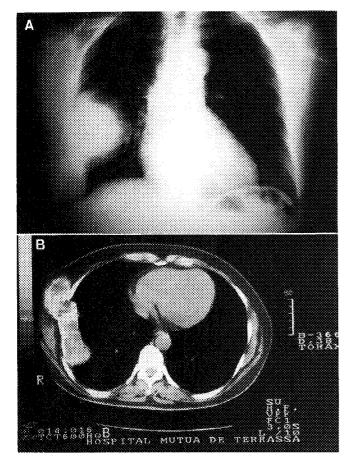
Postero-anterior chest wall radiograph showing multilobulated well defined mass in the right side.
